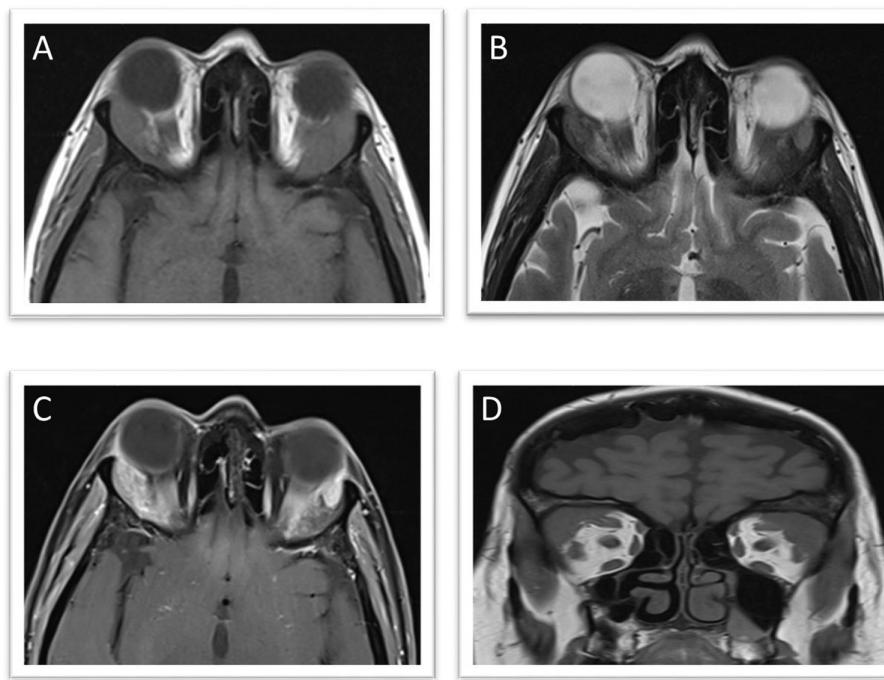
Orbital magnetic resonance imaging findings from the 2022 recurrence. (A) Axial T1-weighted image showing hypointense infiltrative lesions in both orbits. (B) Axial T2-weighted image indicating lesion expansion compared to the prior scan. (C) Axial T1 with fat-suppressed contrast showing diffuse enhancement. (D) Coronal T1 with fat-suppressed contrast indicating bilateral proptosis due to space-occupying effect.
